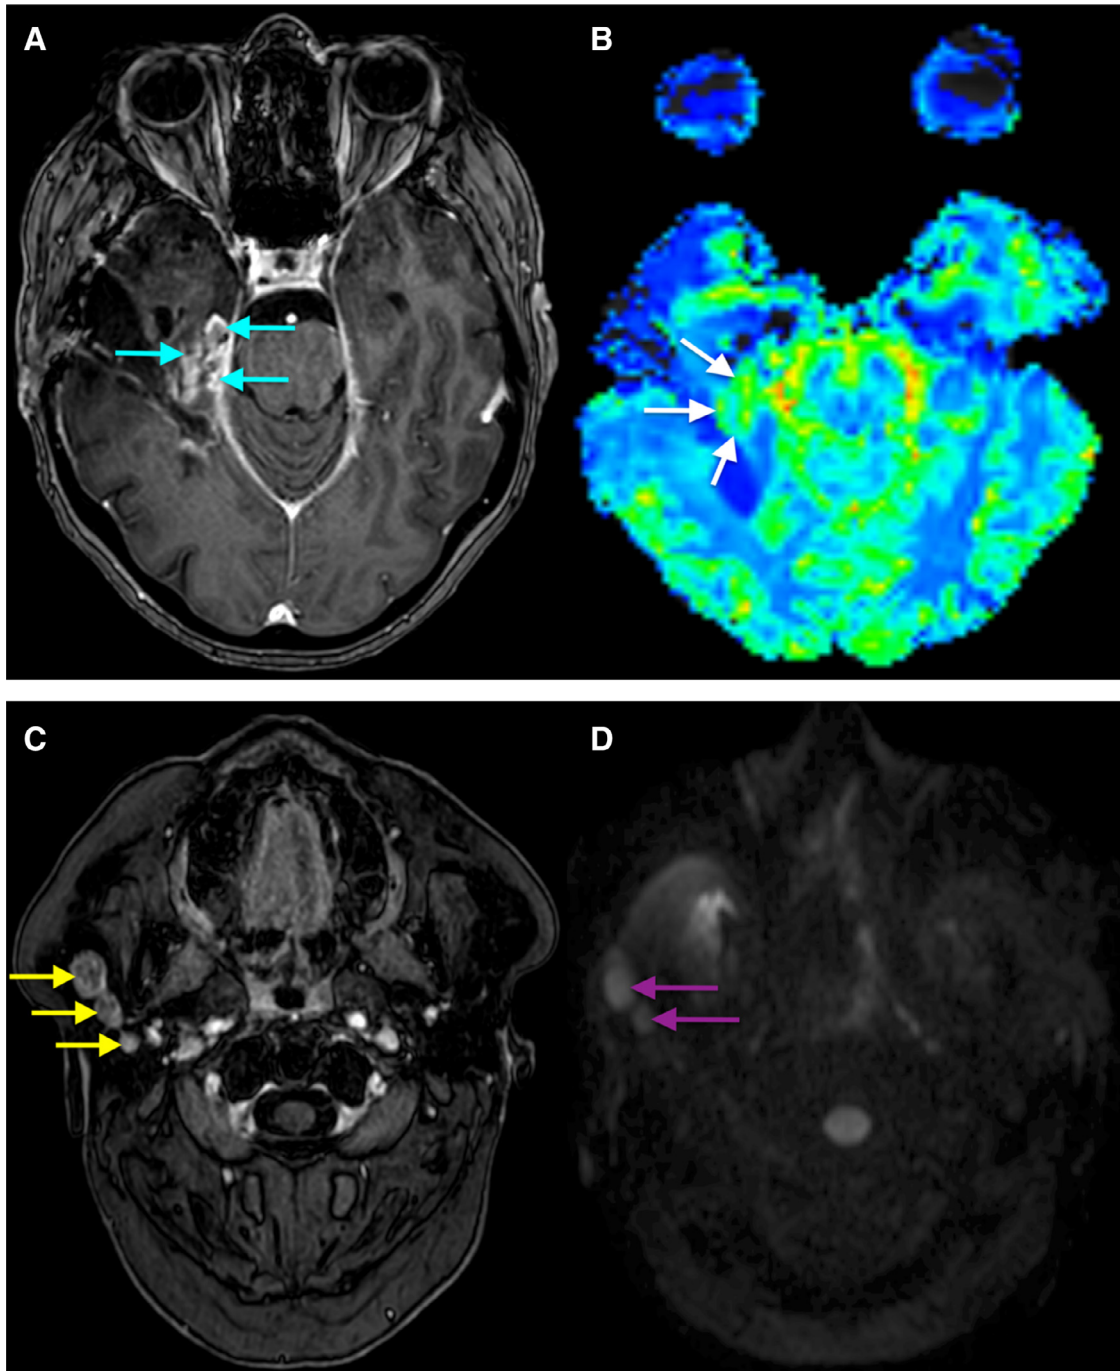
MRI of the brain 3.5 months after presentation. (A) Gadolinium-enhanced T1-weighted image showing nodular recurrence (blue arrows) medial to the resection cavity. (B) Perfusion-weighted imaging showing an increased relative cerebral blood volume (white arrows) in the area of recurrence. (C) Gadolinium-enhanced T1-weighted image showing 3 enhancing nodules (yellow arrows) in the right parotid gland, suggestive of lymphadenopathy. (D) B1000 image demonstrating hyperintensity of the 2 largest parotid nodules (purple arrows). Nevertheless, the parotid nodules were missed on the initial report.
